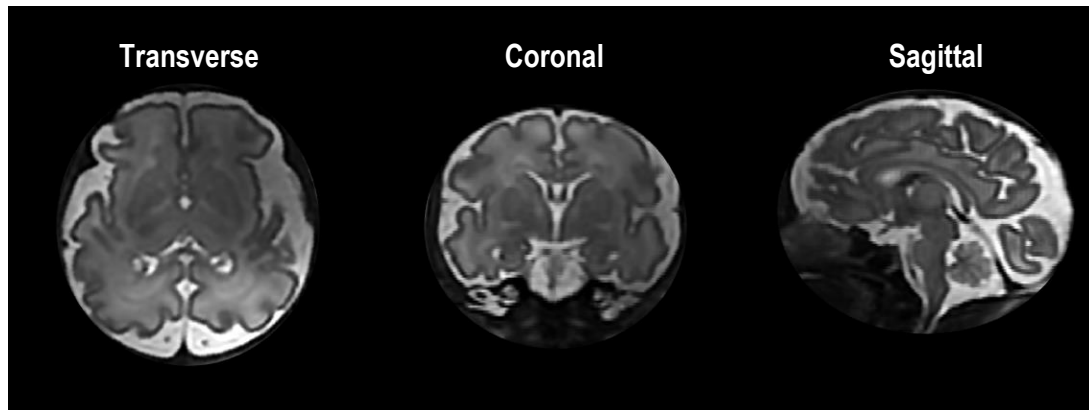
Post-processing of fetal T2-weighted images
